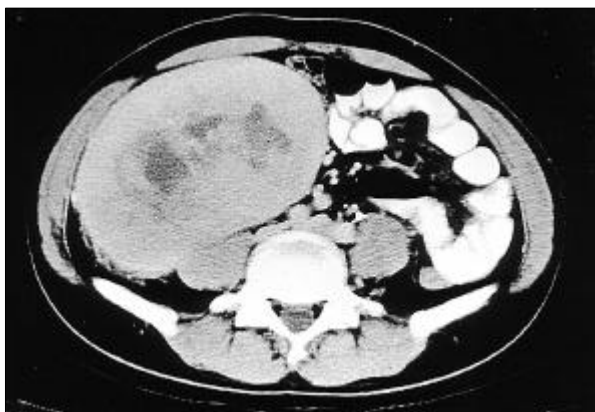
CT scan revealing a 15×16 cm sized, well-demarcated mass with inhomogeneous enhancement and central necrosis originating in the lower pole of the right kidney.
